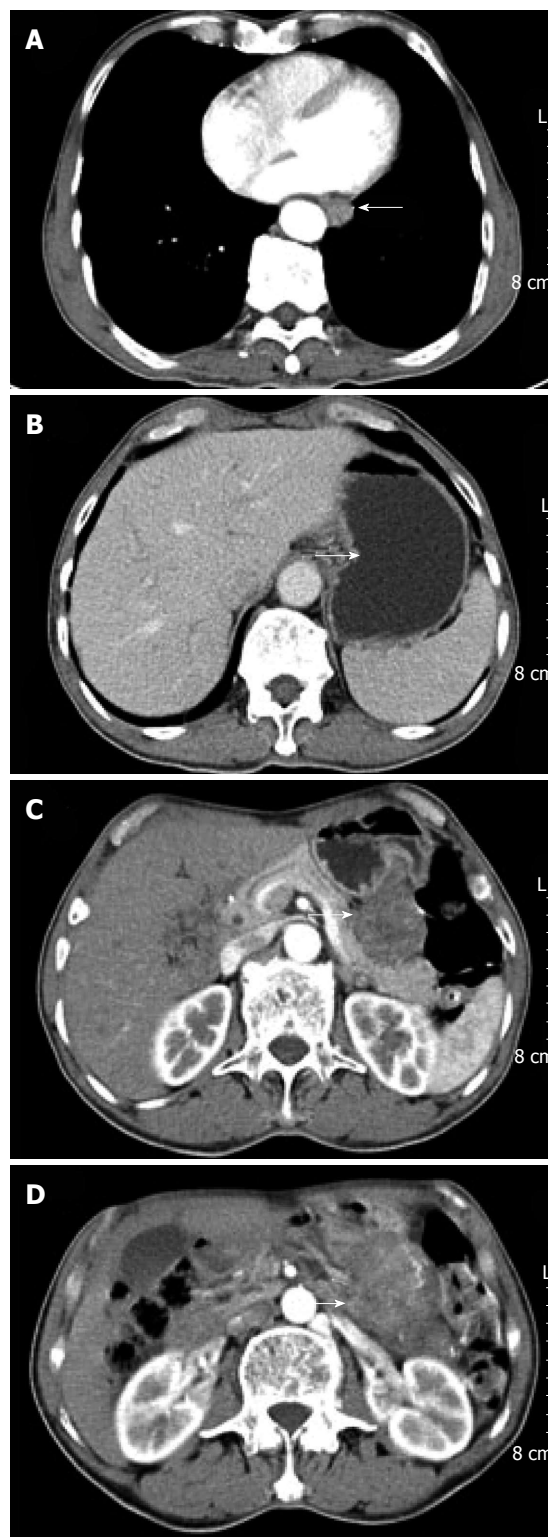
Computed tomography scan. A: Circumferential thickening (arrow) of the lower esophageal wall with loss of lumen; B: Lower level displayed focal thickening (arrow) of the gastric wall with marked enhancement; C and D: Lower levels displayed a large, heterogeneous, round mass close to the greater curvature of the stomach (arrows).
